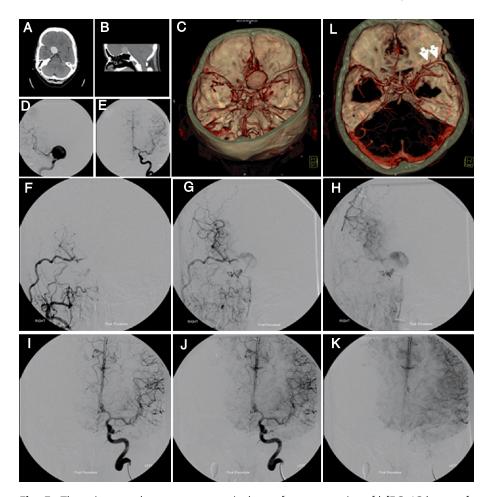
These images demonstrate a typical case from our series of hFEC–IC bypass for giant aneurysms. These images of a 60 year old patient who presented with visual deterioration in the right eye. Her CT head scan (A, B) revealed a right paraclinoid mass which was demonstrated to be a giant carotico-opthalmic aneurysm on a CT angiogram (C). She underwent cerebral angiography which demonstrated good anterior circulation crossflow, but she failed a test balloon occlusion (D, E). She therefore underwent an ECA to M2 bypass, and had a delayed (2 days post bypass) occlusion of her carotid artery endovascularly. The post balloon angiogram demonstrated filling of the right anterior cerebral from the left side as noted preoperatively, and the right middle cerebral territory supplied by the graft (F, G; right common carotid injection; I–K left carotid injection). Following the balloon occlusion, the aneurysm was still noted to be filling (F, G). The patient was reviewed 4 months later when she remained well, the graft (arrows) was patent, and the aneurysm was no longer filling (L). She had no objective change in her visual symptoms
